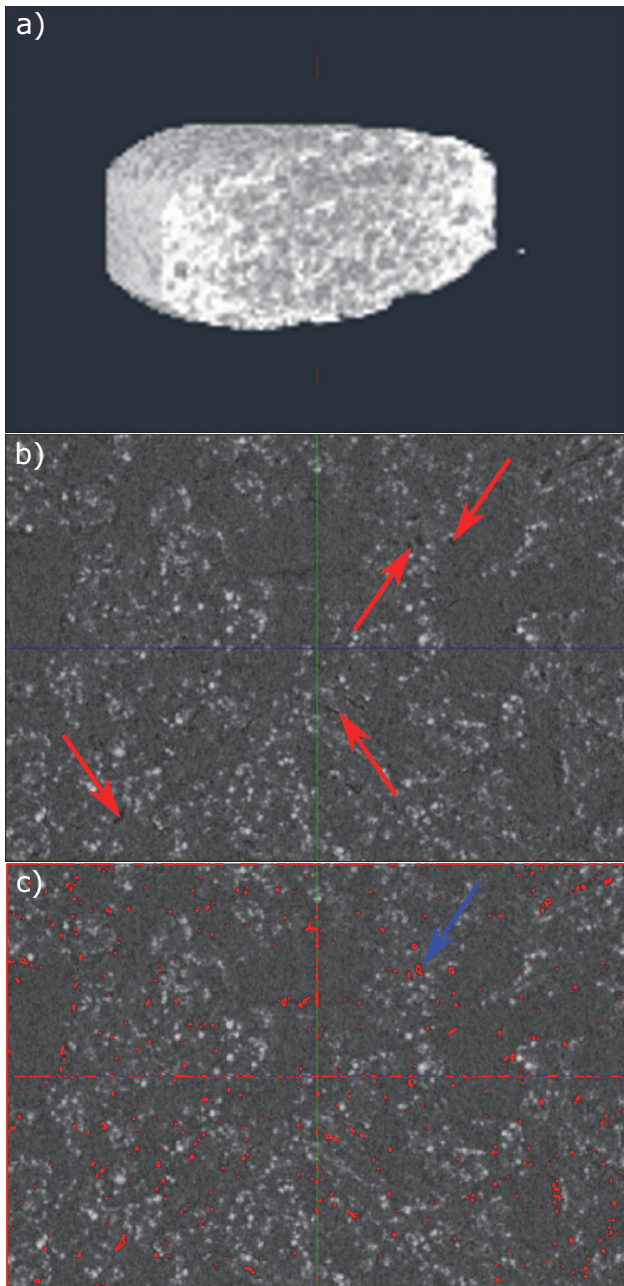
Tomographic μ CT image showing a three-dimensional representation of a tablet cross-section (a), a close-up of the cross-section (b), and the same close-up overlain by a thresholded binary (c). Air pockets are represented by dark grey (b) or red (c). Some large cavities have been marked by red arrows (b). An air pocket of $9\text{-}\mu\text{m}$ diameter has been marked by a blue arrow (c). Frames (b) and (c) correspond to $1.6 \times 1.1\text{-mm}^2$ areas.
